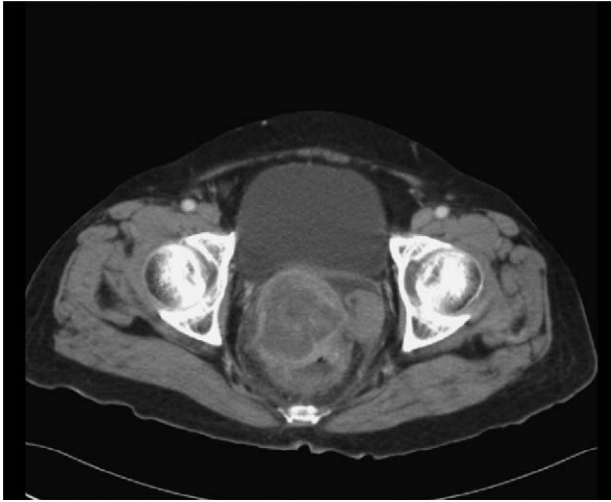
Contrast-enhanced computed tomography revealed a heterogeneous soft tissue mass (6.3×5.3 cm) at rectovaginal space abutting to uterine cervix and rectum.
